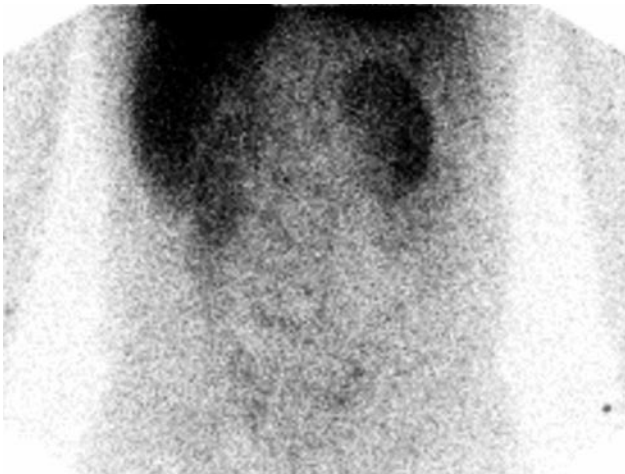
Pulmonary shunt imaging. Static image of the abdomen in posterior projection after injection of technetium-99m macroaggregated albumin particles (99m-Tc-MAA), showing marked pathologic extra-pulmonary tracer uptake in kidneys and liver, compatible with severe pulmonary shunt. The patient underwent subsequent control scintigraphy, with additional imaging of the brain, allowing for shunt quantification according to the following formula:  $(GMBC/0.13)/((GMBC/0.13) + GMLC)$ , where GMBC is the count rate over the brain (geometric mean), GMLC is the count rate over the lungs (geometric mean), and 0.13 represents an assumption of the brain receiving 13% of the cardiac output. This patient's shunt fraction was calculated as 25%.
